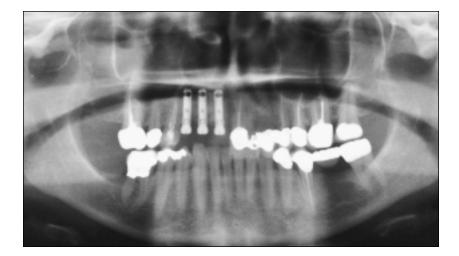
Postoperative panoramic radiograph with parallel implant placement and the adjacent teeth.
